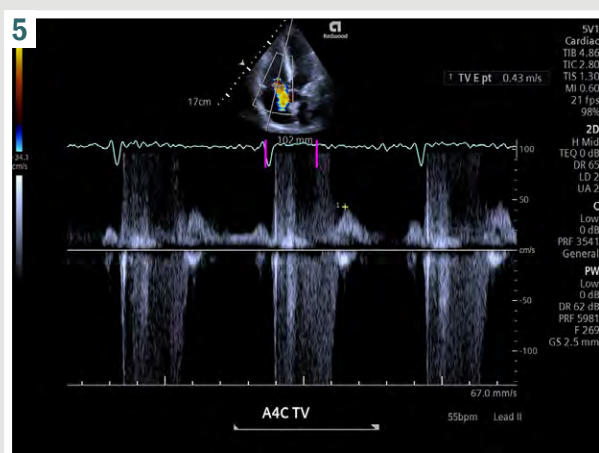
Doppler flow imaging of the tricuspid valve. Both the E-wave and A-wave peaks are observed.
